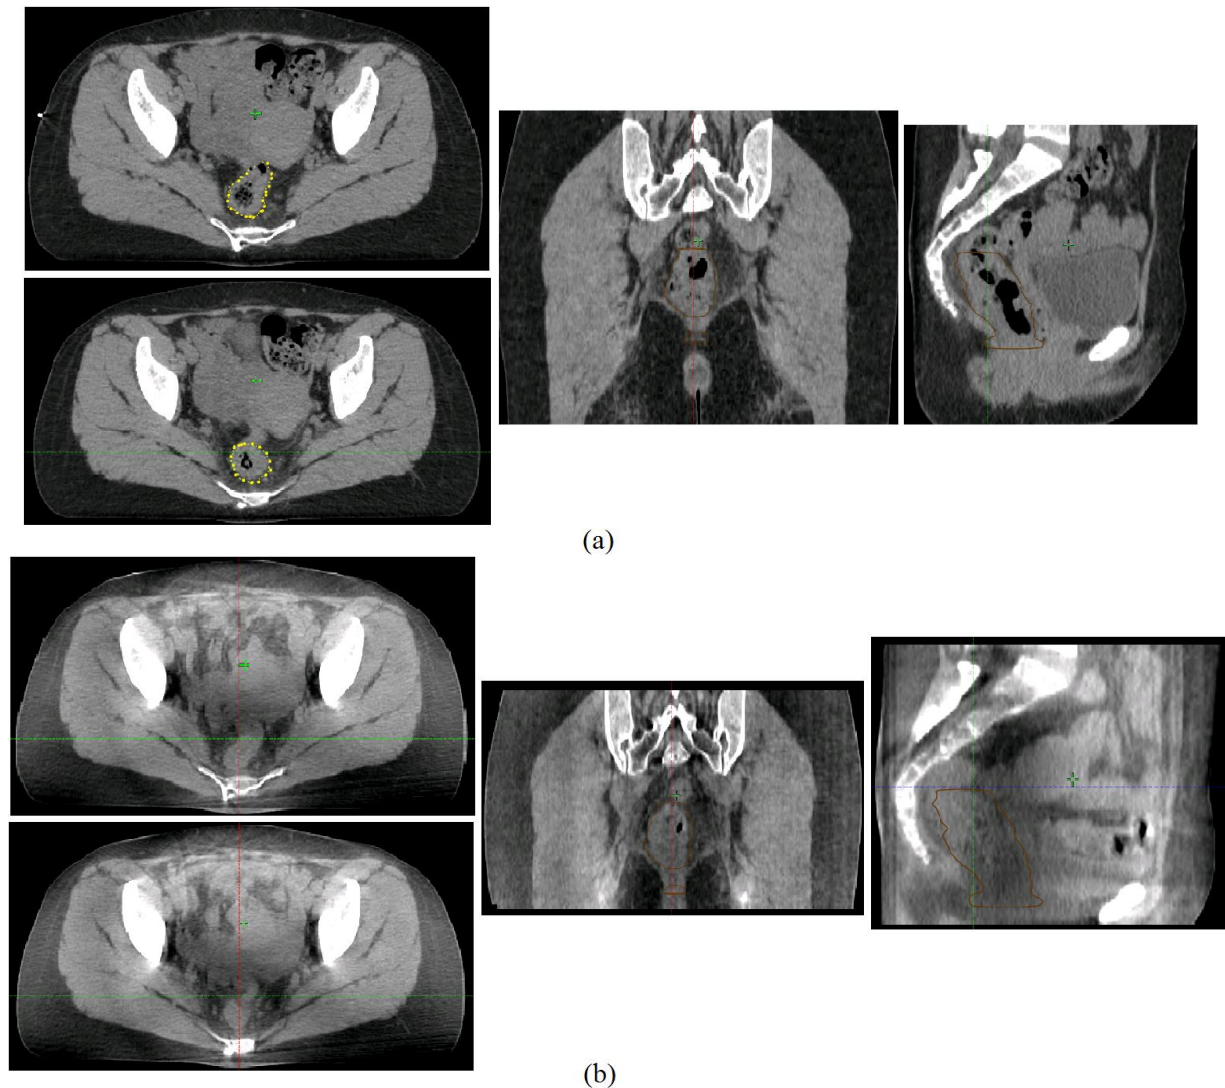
(a) CT scans and (b) corresponding CBCT scans demonstrating the difficulties occurring when delineating a surrogate cranial from the rectum. The upper and lower axial frames in (a) and (b) are separated by a distance of 2 mm. The surrogate is delineated by a brown line and is visible on the sagittal and the coronal frames. The dashed yellow lines in axial frames in (a) represents a suggestion of the surrogate.
